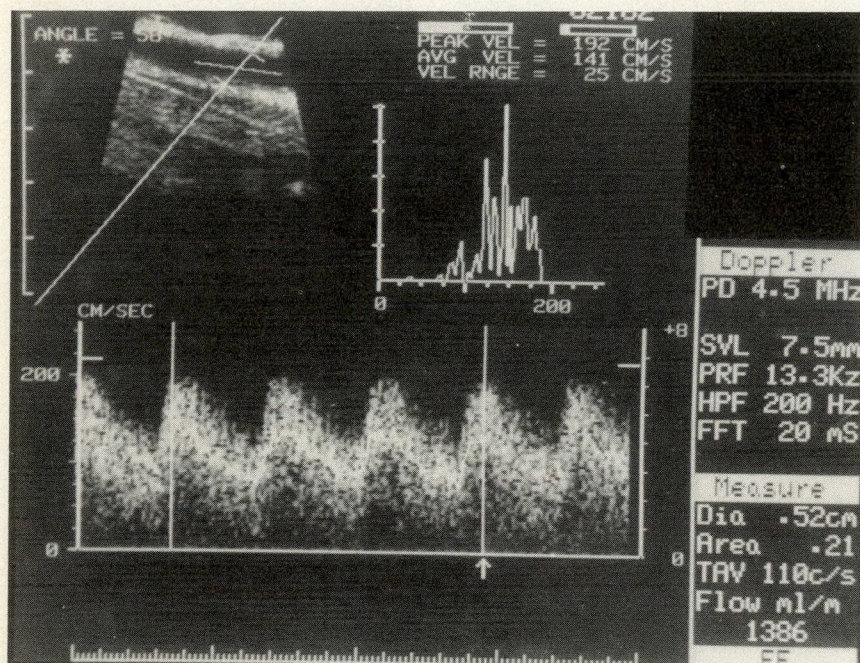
Typical duplex sonographic display of polytetrafluoroethylene (PTFE) graft showing B-mode image with cursor (upper left), Doppler velocity histogram (upper right), Doppler velocity spectrum (bottom) and derived numerical output (lower right).
